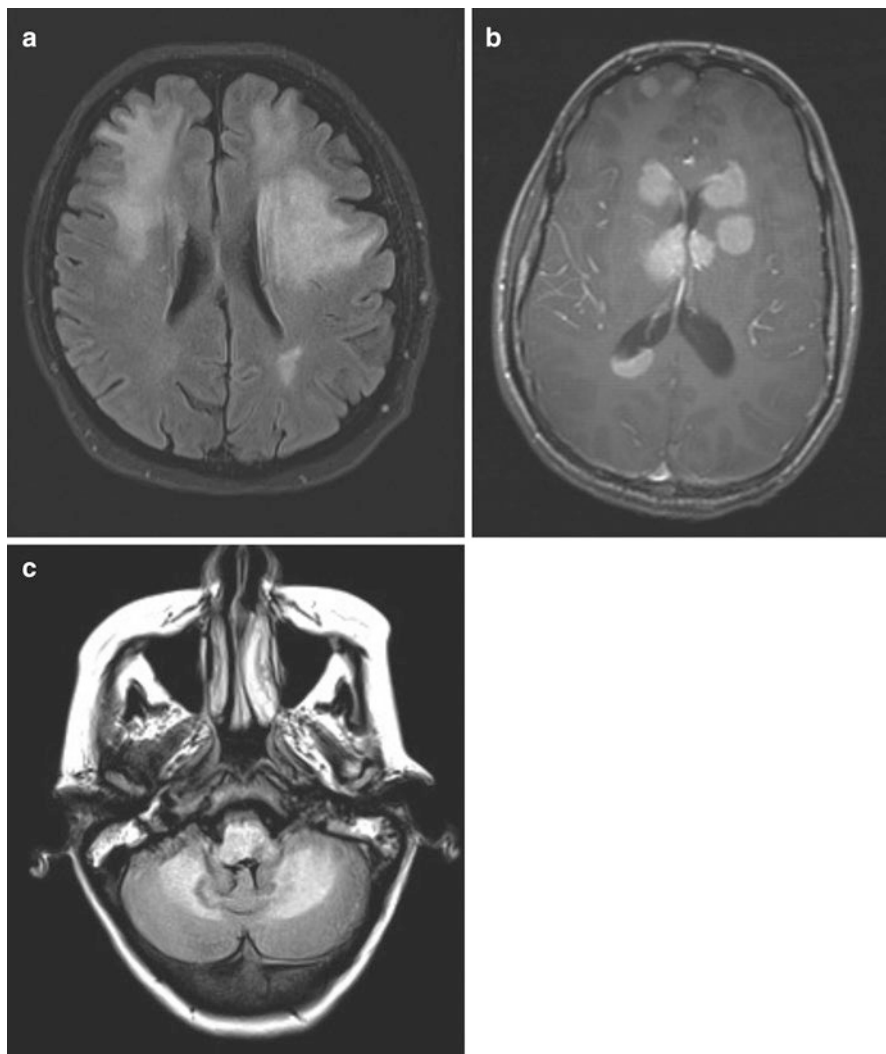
Varied presentations of progressive multifocal leukoencephalopathy. (a) A patient with multiple myeloma received multiple chemotherapy regimens over a 2-year period and was on prednisone for much of this time as well as tacrolimus after an HST transplant. He presented with altered personality, abulia, and a nonenhancing multicentric process in the white matter shown on axial FLAIR images (a). The differential diagnosis included PRES, PML, or drug toxicity. JC virus was found in the CSF. (b) Hematopoietic cell transplant recipient presented 6 months after transplant with rapid onset of confusion and obtundation. Multifocal white matter lesions were found on FLAIR images (not shown), which enhanced vividly after gadolinium. EBV was found in the CSF. T1-weighted gadolinium-enhanced scan shows EBV-associated lymphoma. (c) Patient with untreated CLL developed facial numbness followed over 6 weeks by progressive ataxia and somnolence. JC virus was found in her acellular CSF. As she was untreated, the risk factor for opportunistic infection in this case appeared to be the hematologic malignancy itself rather than immunosuppressive therapy
